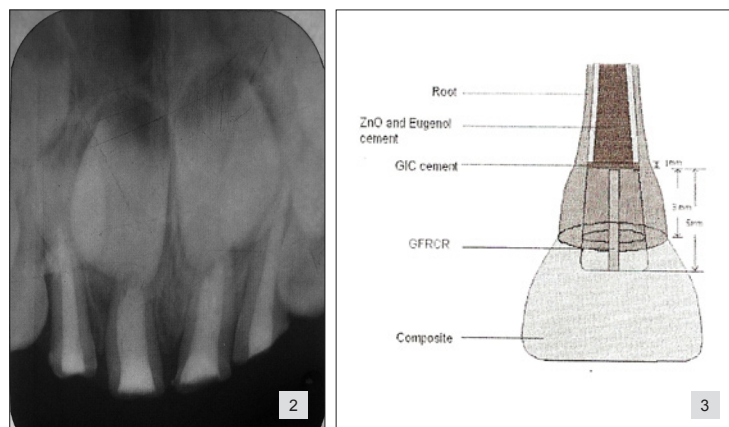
Immediate postendodontic radiograph.
